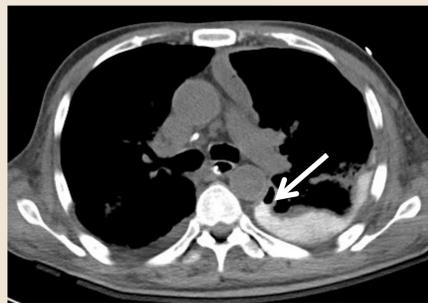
CT thorax with oral contrast. Note leakage of contrast (arrow) into left pleural cavity
